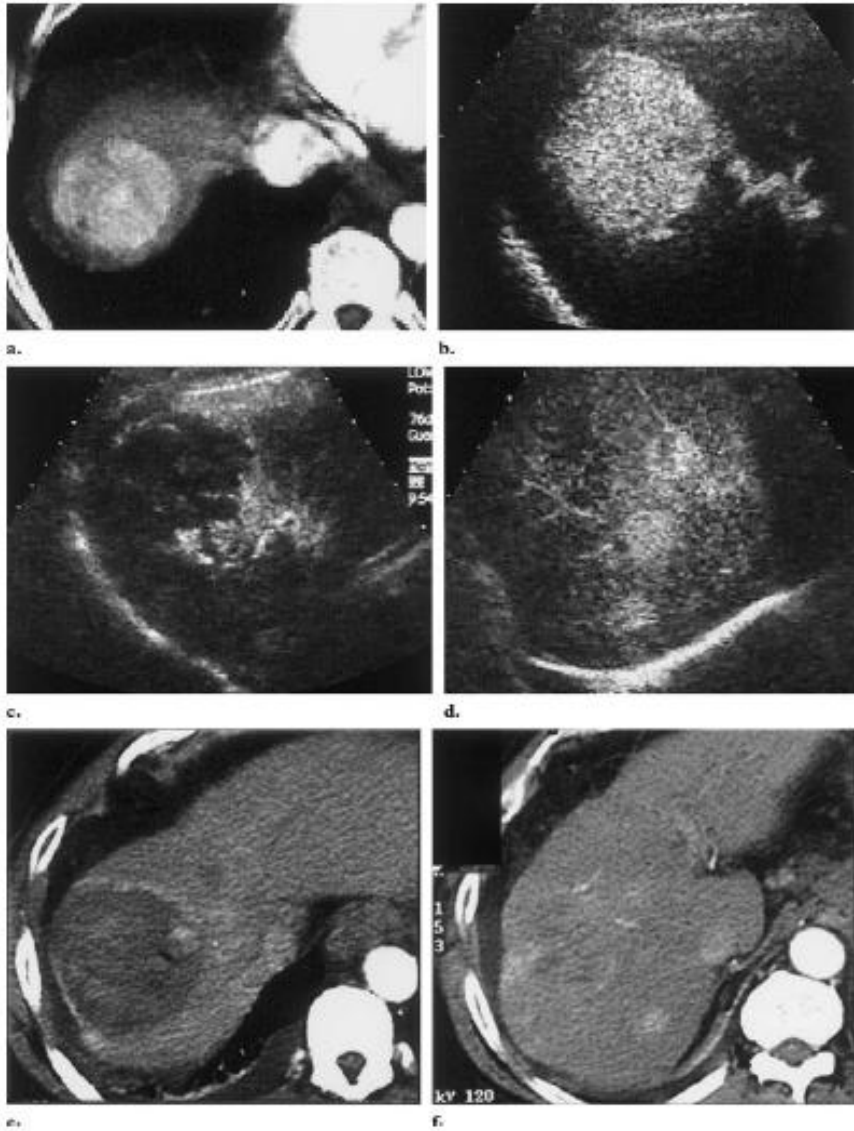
Hepatocellular Carcinoma, with 5.5 cm in diameter, in a patient with 62 years of age. CT images pre-ablation (a) and ultrasound (b) obtained during the arterial phase, showing a hypervascular mass in segment 8 of the liver. Ultrasound contrast images postablation showed two small (1.8 cm and 1.2 cm in diameter) nodules of viable tumor tissue in the caudal portion of mass (c) and new small foci of hepatocellular carcinoma in segment 6 (d). Additional CT images show that the ablated area with small foci of residual tumor (e) and new recurrent nodules in the most caudal portion of the liver (f).
